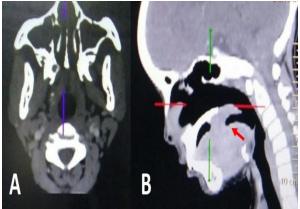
CT Scan (A) Axial View (B)
